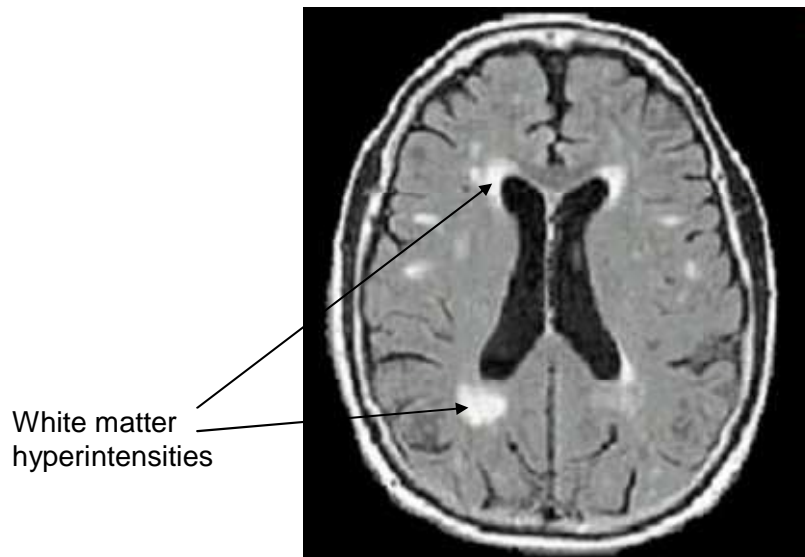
CT scan of a human brain
